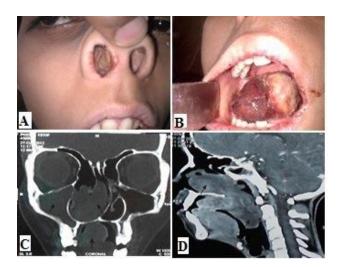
(A and B) Preoperative photographs showing infected antrochoanal polyp right nasal cavity and prolapsed part in oropharynx. (C and D) CT scan PNS coronal section and sagittal section showing homogenous soft tissue opacification in Rt maxillary sinus, Rt nasal cavity and nasopharynx and oropharynx.
